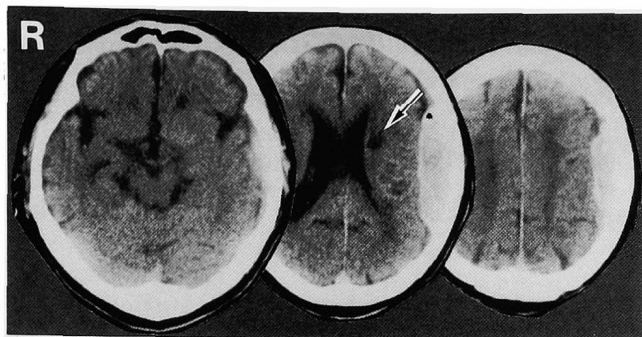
Initial computed tomography scans 1 hour after the accident revealing a lentiform, homogeneous hematoma in the left temporal extracerebral region. Note the atrophic brain with old infarction in the corona radiata (arrow).
